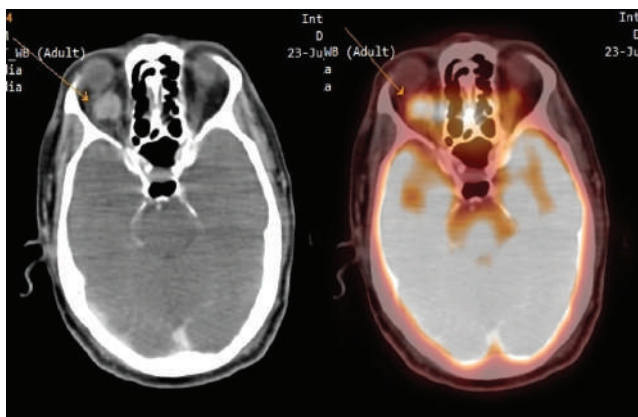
Axial CT and fusion PET-CT images demonstrate a well-defined, hypermetabolic (FDG-avid) soft tissue lesion within the right orbit.
